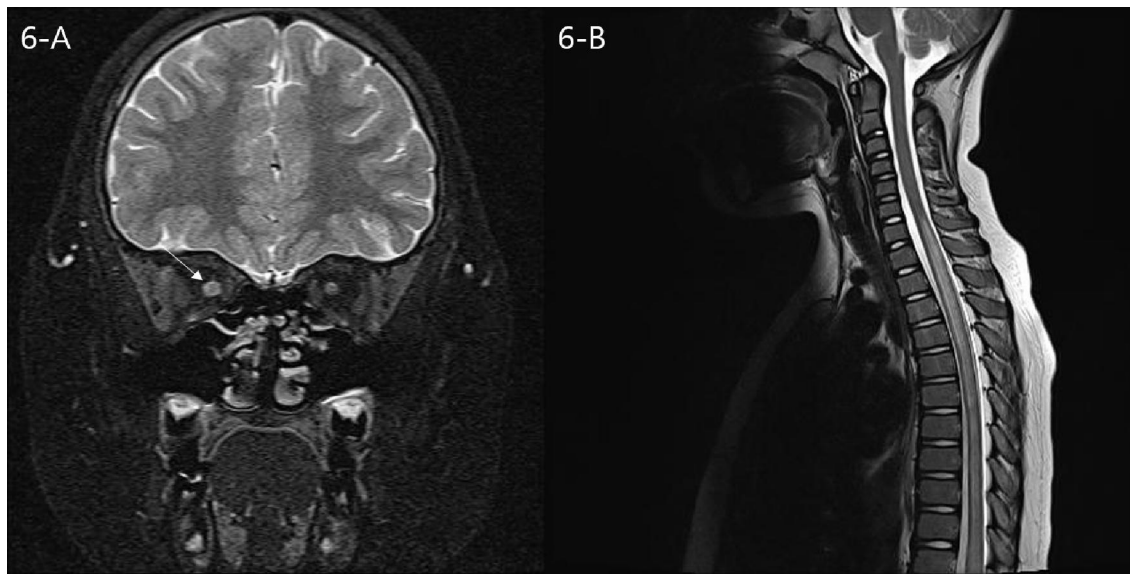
Orbit and spine MRI of patient 47 diagnosed with (MOG antibodies positive). The T2 high signal intensity lesion and swelling of right optic nerve is shown on the T2 weighted image (A). Diffuse spinal cord lesion with high signal intensity is shown on the T2 weighted image (B). MRI, magnetic resonance imaging; FLAIR, fluid-attenuated inversion recovery; MOG, myelin oligodendrocyte glycoprotein
